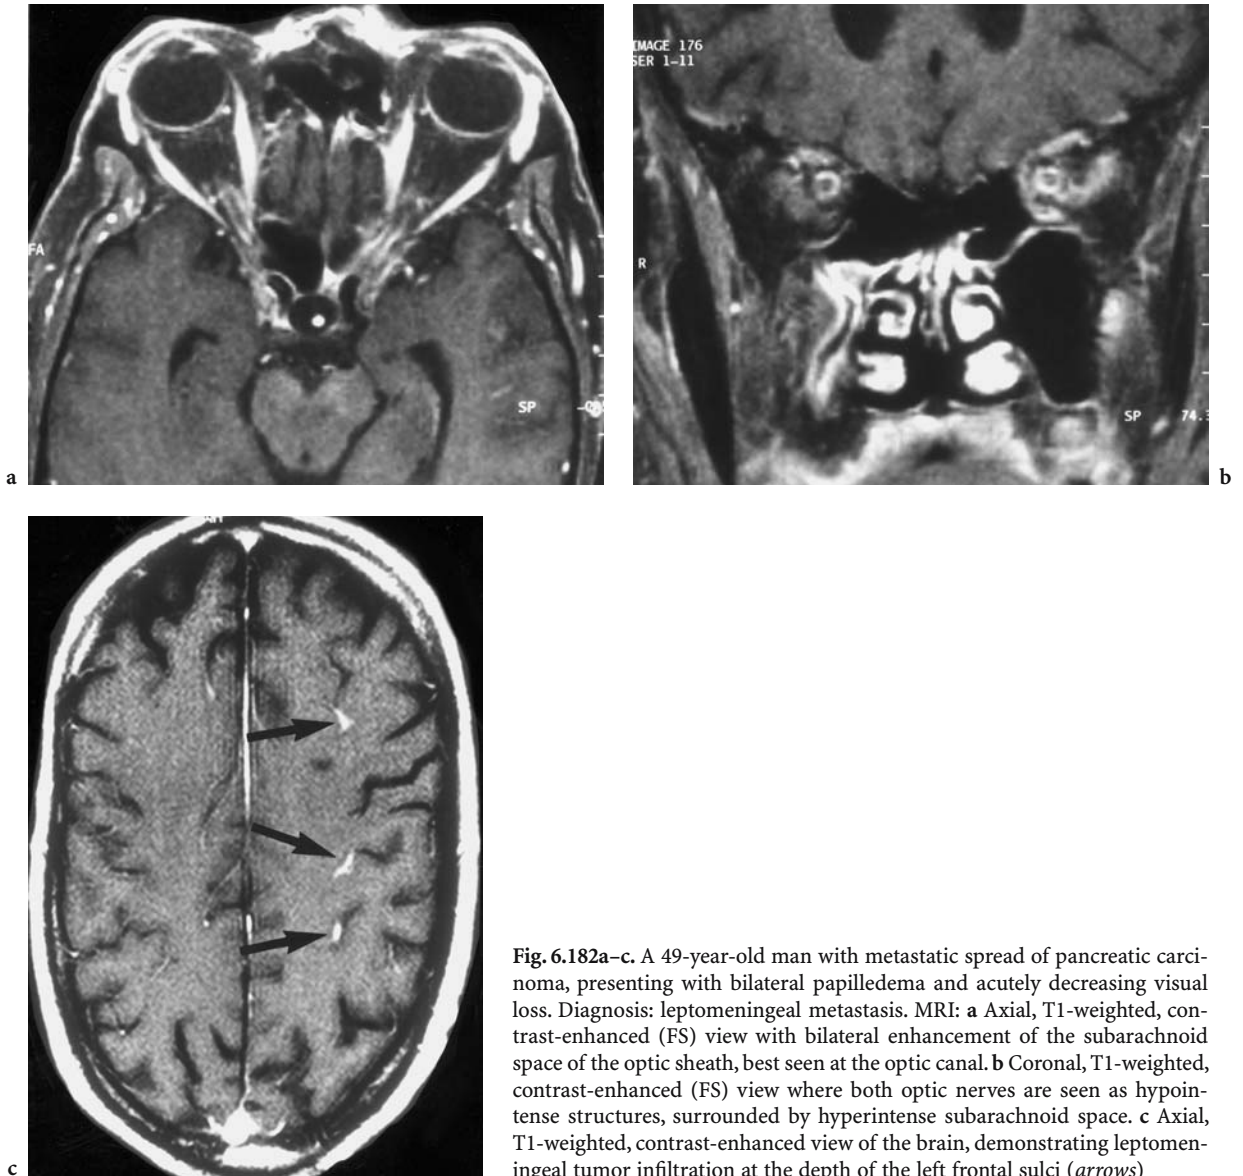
A 49-year-old man with metastatic spread of pancreatic carcinoma, presenting with bilateral papilledema and acutely decreasing visual loss. Diagnosis: leptomeningeal metastasis. MRI: a Axial, T1-weighted, contrast-enhanced (FS) view with bilateral enhancement of the subarachnoid space of the optic sheath, best seen at the optic canal. b Coronal, T1-weighted, contrast-enhanced (FS) view where both optic nerves are seen as hypointense structures, surrounded by hyperintense subarachnoid space. c Axial, T1-weighted, contrast-enhanced view of the brain, demonstrating leptomeningeal tumor infiltration at the depth of the left frontal sulci (*arrows*)
